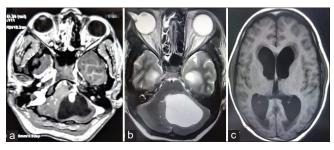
(a) Contrast-enhancing magnetic resonance imaging revealed an intra-axial mass lesion of 5.4 \times 4.5 \times 3 cm dimension in the left cerebellar hemisphere, enhancing nodule with marked distortion of cerebellar hemisphere, with brain stem compression. (b) T2 axial image showing hyperintense lesion with perifocal edema around the tumor. (c) T1-weighted image showed enlargement of both lateral ventricles and ballooning of the third ventricles with periventricular lucency suggestive of hydrocephalus.
